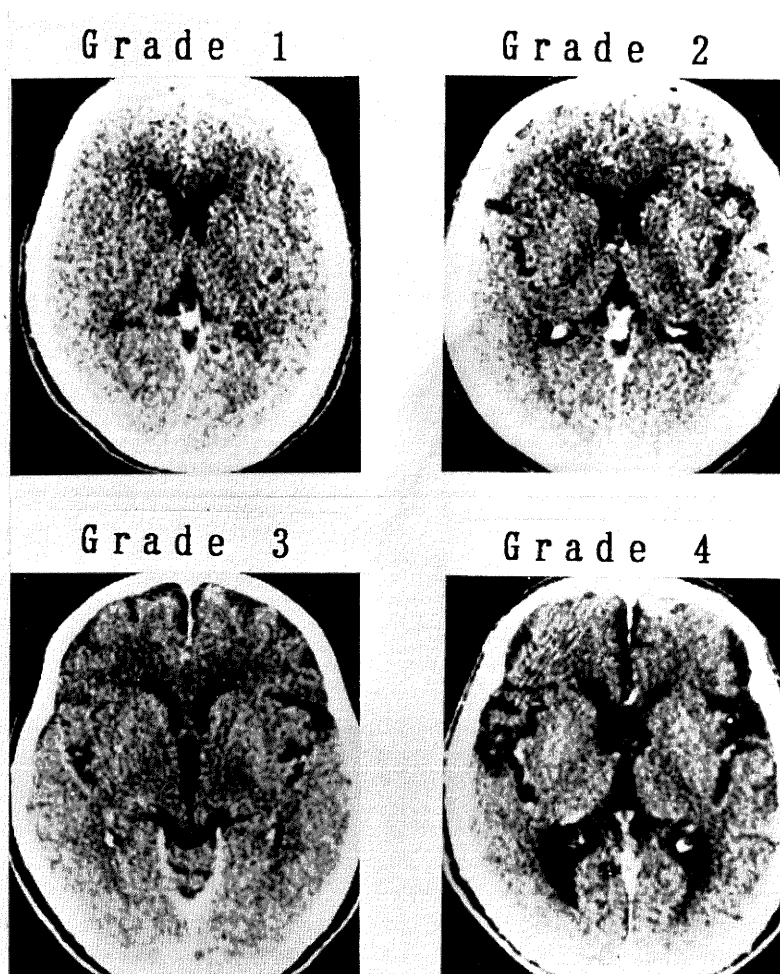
Grading of cerebral atrophy on CT, on the basis of the widening of the sulci and dilatation of the ventricles (1=normal; 4=most abnormal).
